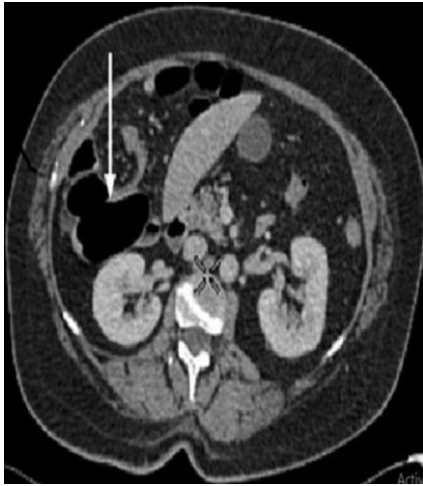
CT scan of 45 year female, demonstrating-whirl sign at the point of caecal volvulus (arrow).
